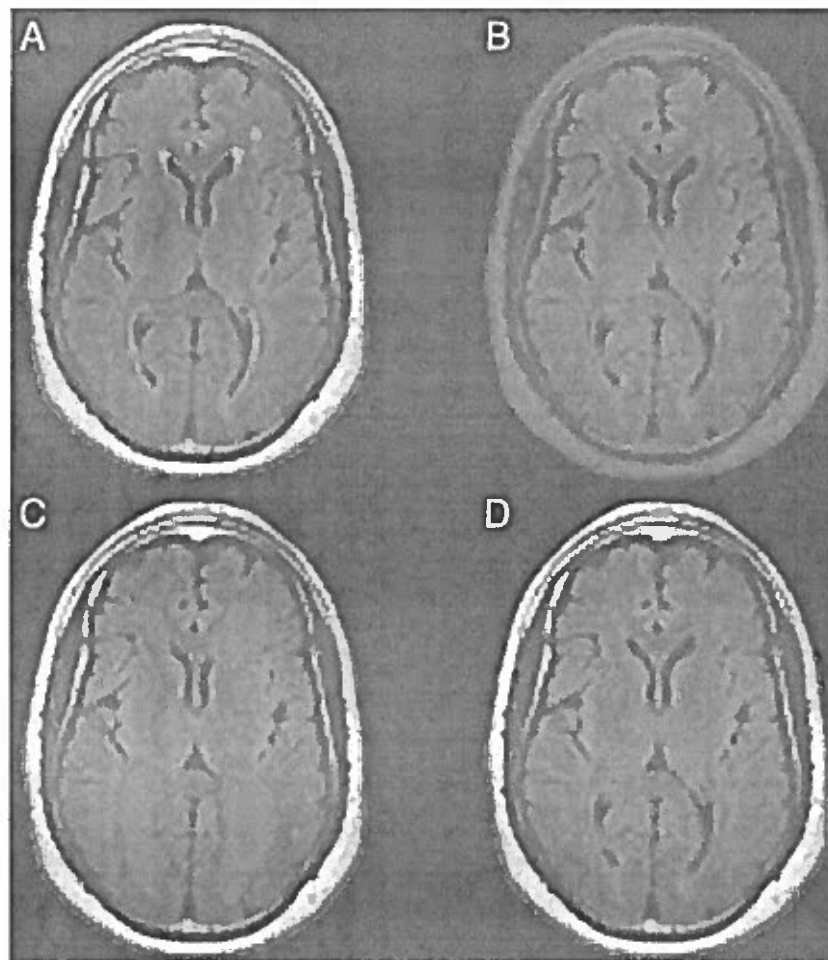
(A) Original grayscale MRI axial FLAIR image from a representative subject; (B) region of interest (ROI) map created by semiautomatic intensity thresholding; (C) ROI map created by gross manual outlining of hyperintensities; (D) intersection of (B) and (C) yielding hyperintensity locations.
